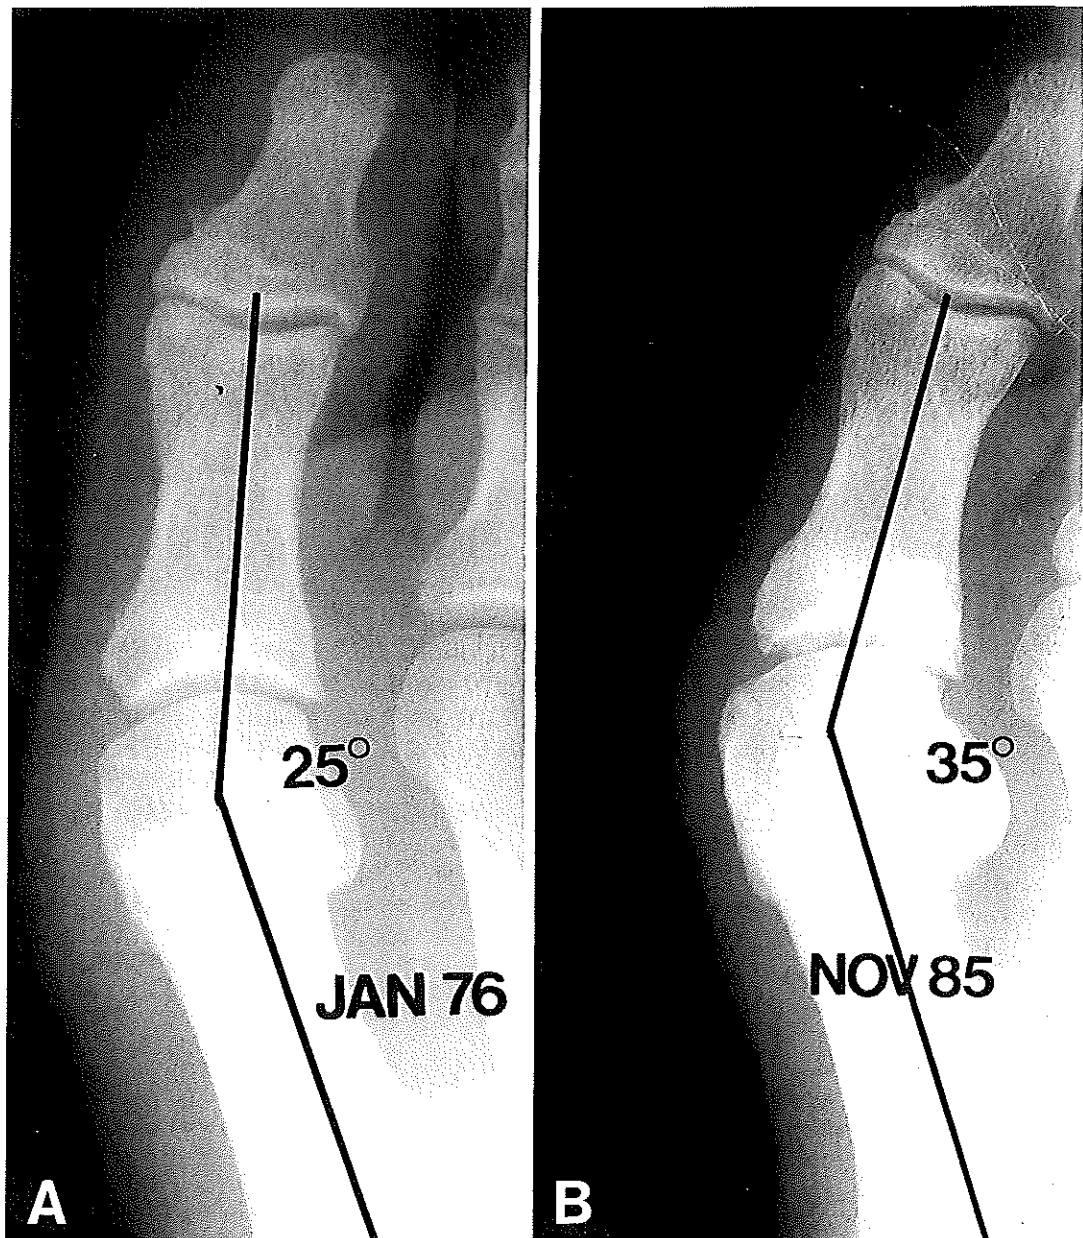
Hallux valgus developing after grade 3 turf toe injury. A, AP radiograph taken 5 months postinjury demonstrating 25 degree HV angle. B, AP radiograph taken almost 10 years later showing increase in HV angle to 35 degrees and early degenerative changes.
